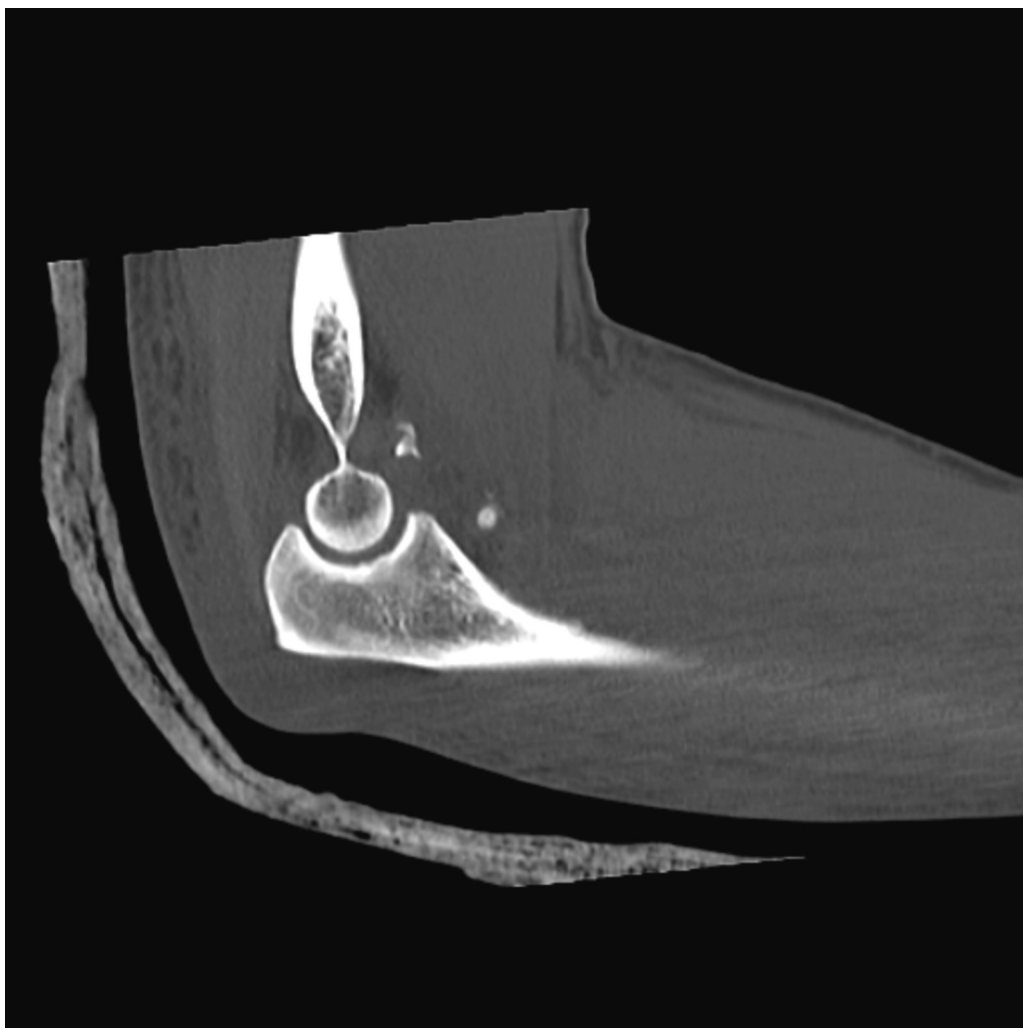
Computed tomography in a sagittal section of the elbow with coronoid apophysis fracture.
